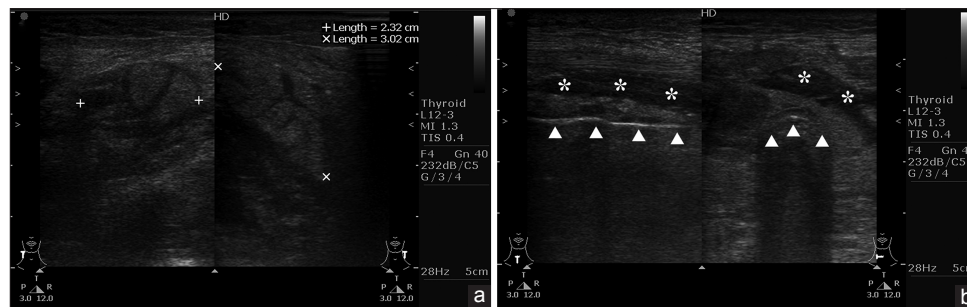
Focused ultrasound showed (a) cobblestone over the submandibular and submental region (cursors) and (b) subcutaneous edema filling the interlobar septae rather than abscess formation (asterisks) and the exact position of the tracheal ring (arrowheads)
